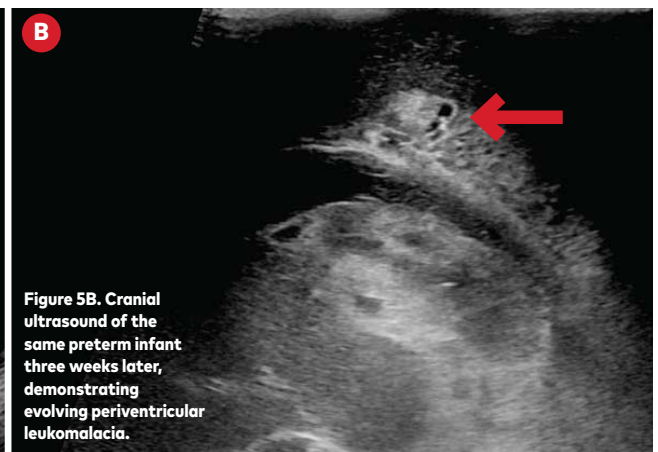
Cranial ultrasound of the same preterm infant three weeks later, demonstrating evolving periventricular leukomalacia.
